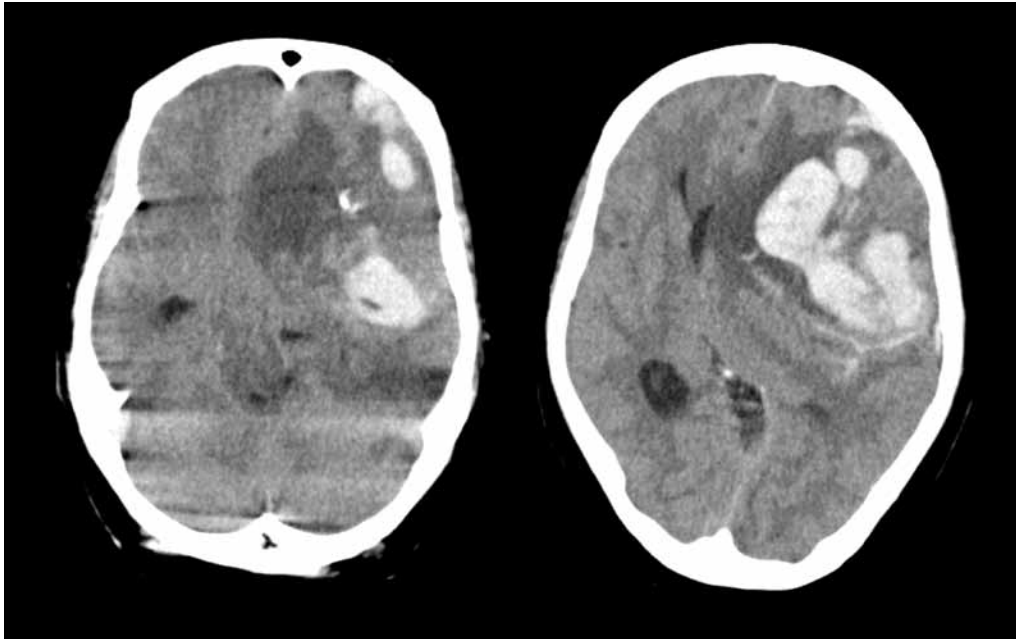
Computed tomography revealed a mass with a large hematoma and focal calcification in the left frontal lobe. Both the frontal and temporal lobes were herniated and the brainstem was compressed.
